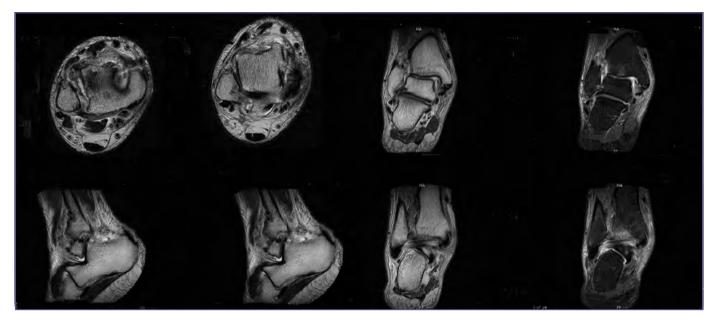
MRI of the right ankle 1 month after accident.
